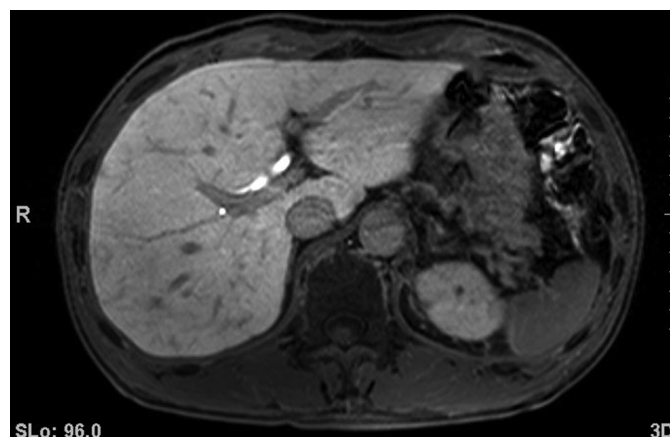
6 months after the treatment, the lesions had almost disappeared and only a few scars were persistent. Hepatobiliary phase sequence of the enhanced MRI using Gd-EOB-DTPA.
